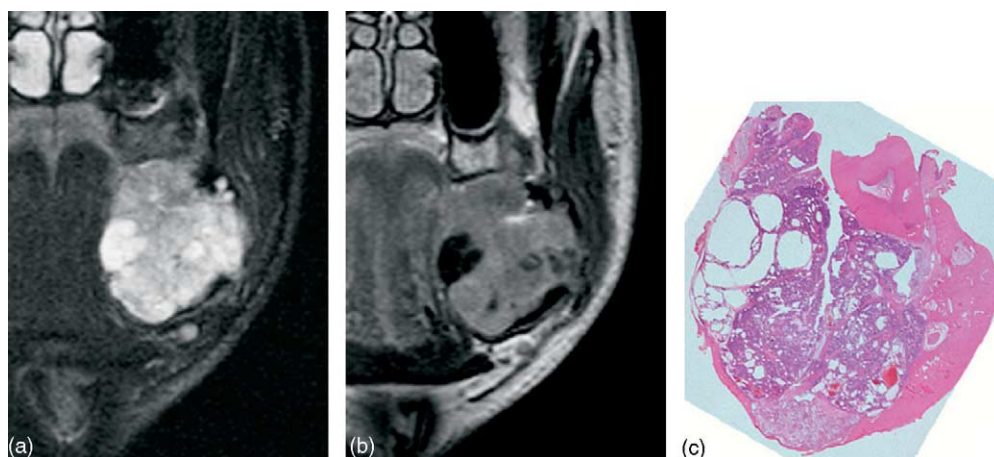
Case 2: 27-year-old male. (a) Axial T2-weighted MR image shows a well-defined focal mass of heterogeneous high signal intensity with an extremely high signal spot at the left mandible (TR/TE = 4000/90). (b) On Gd-T1WI, there is well enhancement in the lesion. However, the area corresponding to the intermediate signal spot on T1WI and the extremely high signal spot on T2WI shows no enhancement on Gd-T1WI (TR/TE = 700/12). (c) Gross features of the resected tumor correspond to the coronal section of the MRI.
